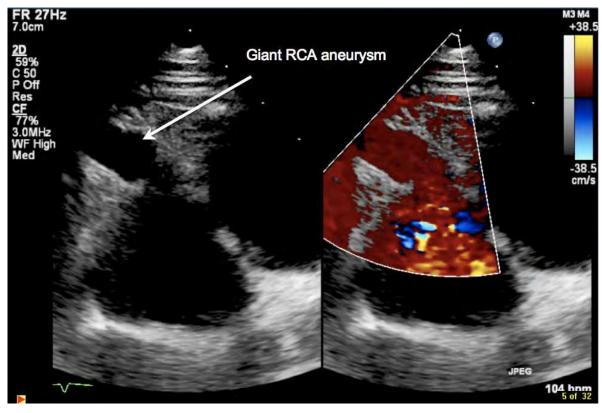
Parasternal short axis image showing a giant aneurysm of the right coronary artery (RCA).
